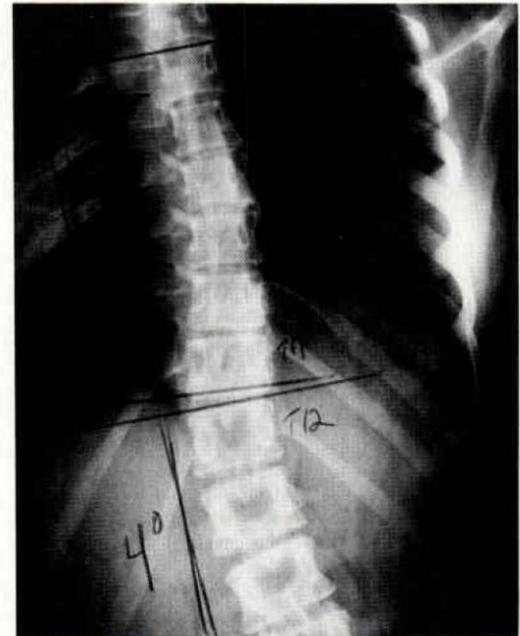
x-ray—A radiographic film denoting shift movement indicating flexibility and muscular correctional control patient can exhibit. Note; right thoracic now 7 degrees and left lumbar, now 4 degrees.
